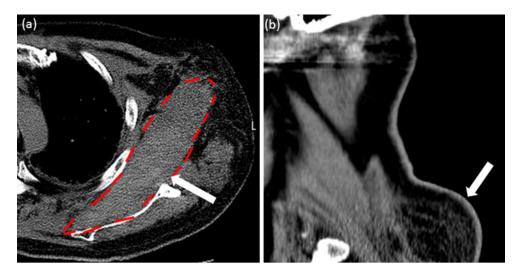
HRCT scan of the back showing of a intramuscular hemorrhage from left deltoid (*arrow*), hematoma (enclosed by the *dotted line*) and b intramuscular hematoma in trapezius muscle (*arrow*). *HRCT* high-resolution computed tomography
